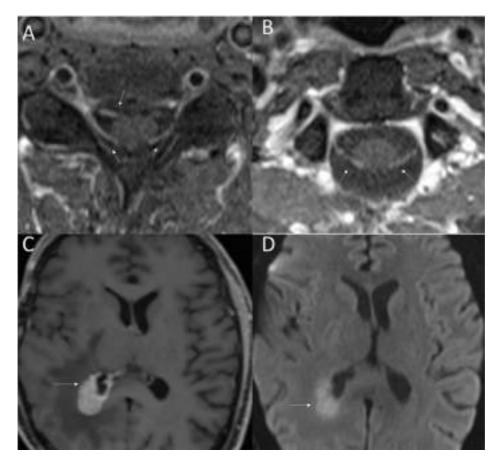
Follow up MRI of the cervical spine (A and B) and brain (C and D) after I-year of initial presentation with progression of neurolymphomatosis. Axial (A and B) contrast-enhanced TI-weighted MR images of the cervical spine with thickening and enhancement of multiple dorsal and ventral nerve roots. Contrast-enhanced TI-weighted MRI of the brain reveals nodular enhancing lesion with ependymal involvement in the right peritrigonal region (C, arrow). Lesion shows restricted diffusion (D, arrow) suggesting high cellularity.
